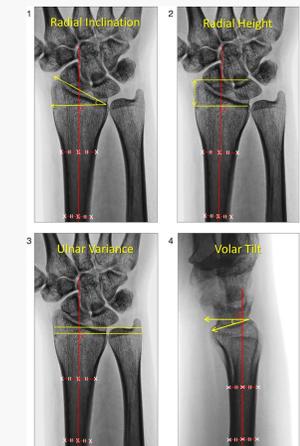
Radiographic measurements⁶
